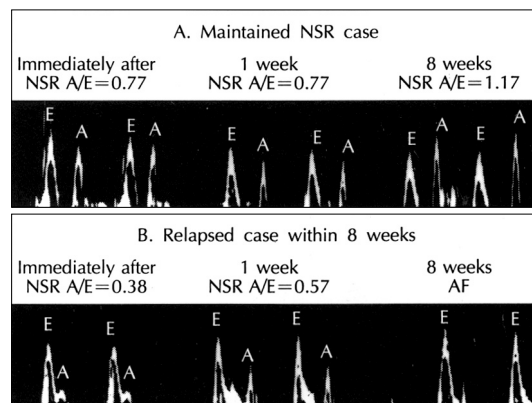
Serial evaluation of atrial function using PW Doppler post-cardioversion.
